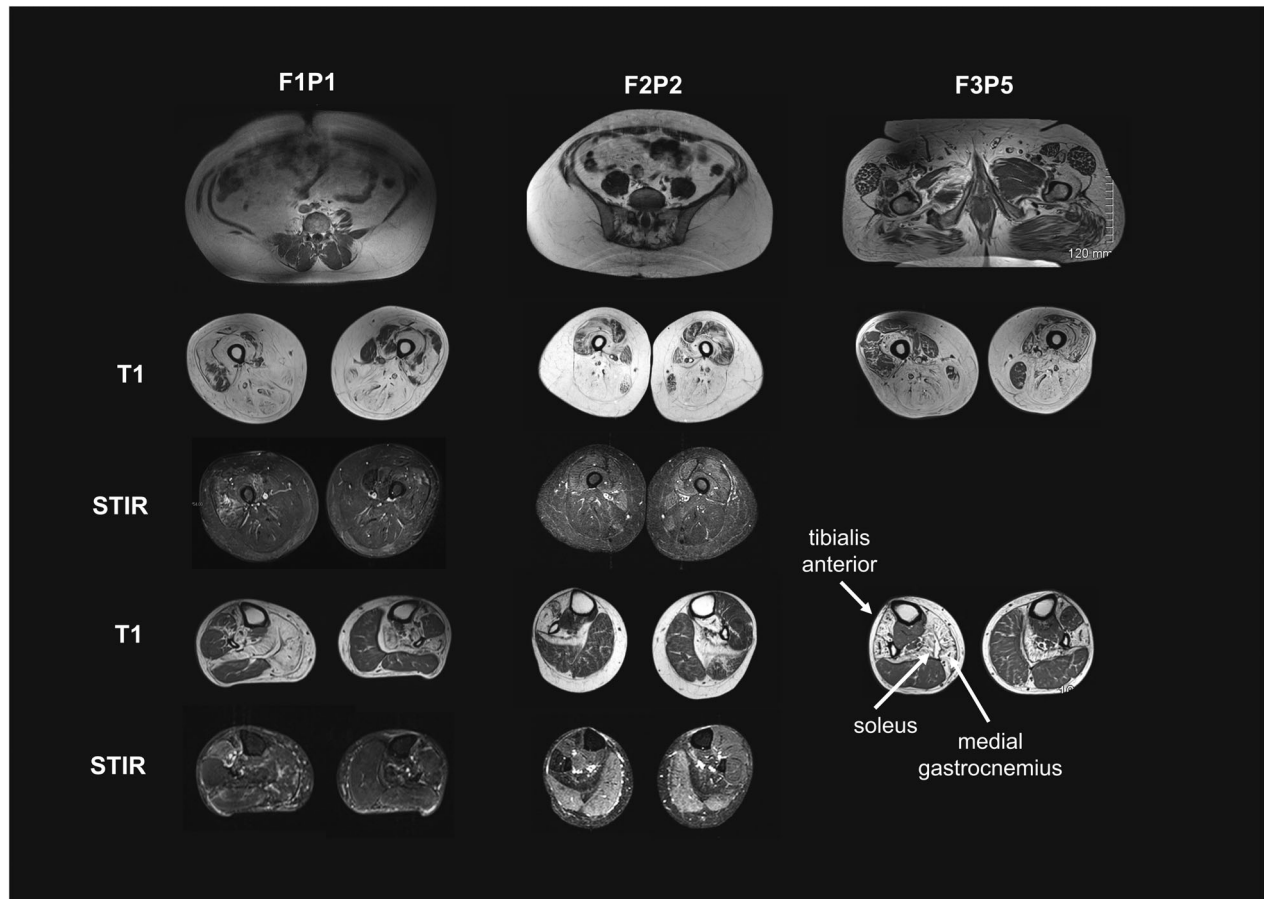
Muscle MRI imaging in patients with biallelic *ACTN2* variants. Lower extremity T1 axial images in patients F1P1 (age 44 years), F2P2 (age 53 years), and F3P5 (age 61 years) reveal severe atrophy and T1 hyperintensity in the thigh muscles with almost complete replacement of the posterior compartment (hamstring muscles) and medial compartment (adductors) with fibroadipose tissue. There is also notable asymmetric involvement of the anterior thigh (quadriceps) muscles, with patchy abnormal signal (right > left) in patient F1P1 and (left > right) in patient F3P5. In the lower leg muscles, selective involvement of the soleus muscle is seen in all three patients. There is evidence of strikingly asymmetric involvement of the medial gastrocnemius, with fibroadipose tissue replacement on the right and relative sparing on the left (in F1P1 and F3P5). Similarly, the tibialis anterior muscle demonstrates strikingly asymmetric involvement, with severe involvement on the right and relative sparing on the left (in F2P2 and F3P5). Also of note is evidence of STIR positivity in muscles with normal T1 signal, as demonstrated in left tibialis anterior muscle of F1P1 and the medial and lateral gastrocnemius muscles of patient F2P2.
